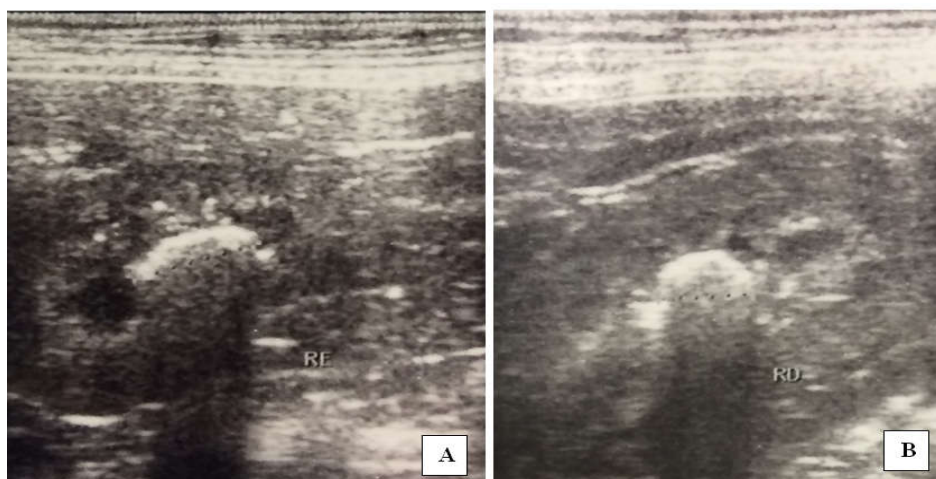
(A) Ultrasound evaluation of the left kidney region. Figure 2. (B) Ultrasound evaluation of the right kidney region. Observe in both images, symmetrical kidneys, with contour and echogenicity preserved and evidencing the presence of structures forming bilateral acoustic shadows and measuring about 1cm diameter in the left kidney and 0,7cm in the right kidney.
